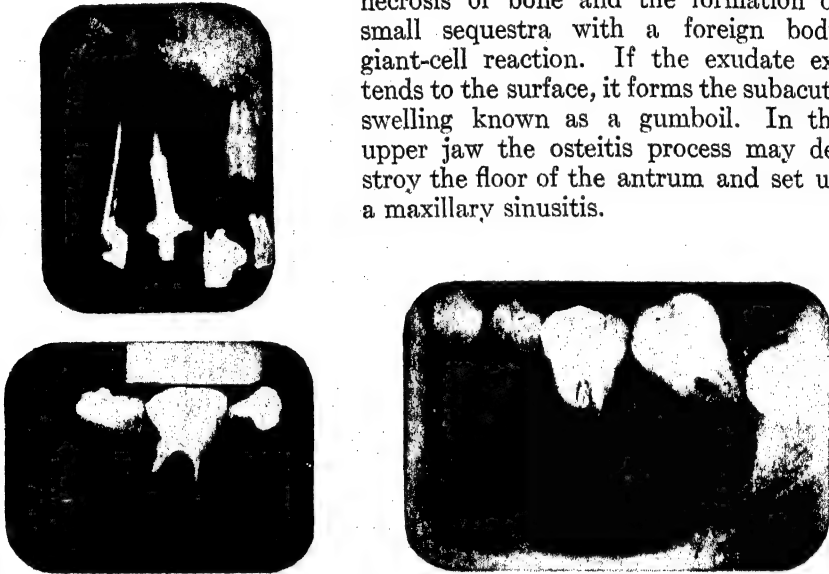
Cystic areas associated with periapical infection. (Hill, Oral Pathology.)
